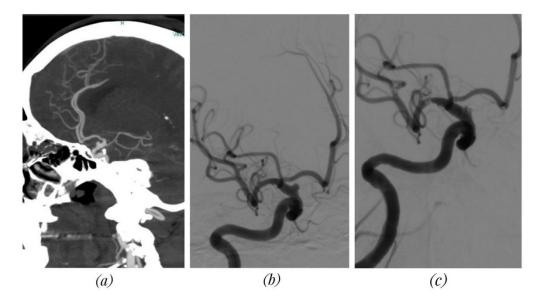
A 52-year-old woman was admitted to the National Brain Center Hospital with complaints of a sudden and severe headache that had been felt for 3 days before admission. After performing a Digital Subtraction Angiography (DSA) of the brain, a saccular aneurysm was found in the supraclinoid segment with a neck size of 3 mm and a dome size of 3.2 mm x 2.7 mm superiorly. (a) CTA images showed an aneurysm (b) DSA images obtained before SAC (c) DSA images obtained after SAC.
